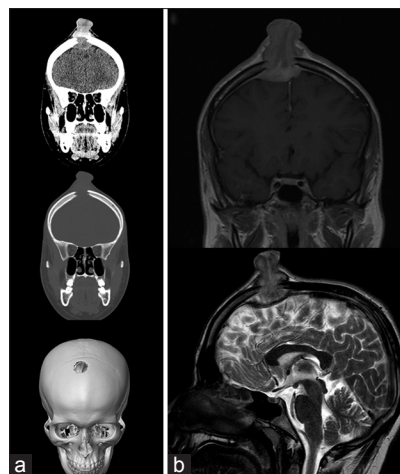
Images for the patient in case 2. (a) Computed tomography head without contrast. Coronal brain window (top), coronal bone window (middle), and three-dimensional skull reconstruction (bottom) images. (b) Magnetic resonance imaging brain. Coronal postcontrast T1-weighted image (top) and sagittal T2-weighted (bottom) images
